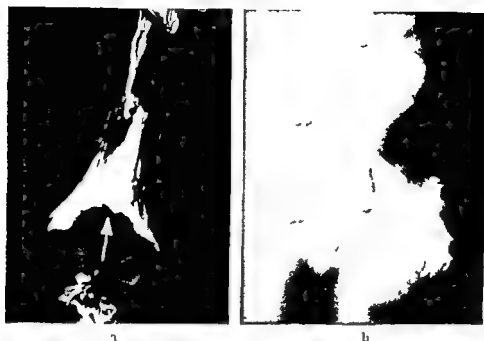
a) Cast of the fourth ventricle. Arrow points to fistigium. b) Lateral roentgenogram of cast. A pin marks the fistigium; the superior posterior recesses extend more dorsally and caudally than the fistigium.
